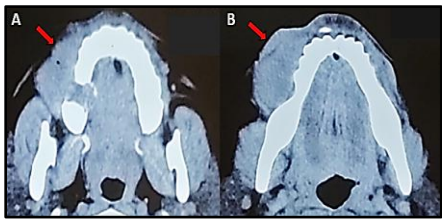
A and B. Axial sections of contrast enhanced CT (CECT) showing a well-defined heterogeneously enhancing soft tissue lesion in right posterior maxilla arising from edentulous 1st molar region with erosion of buccal and palatal cortices (red arrows).
